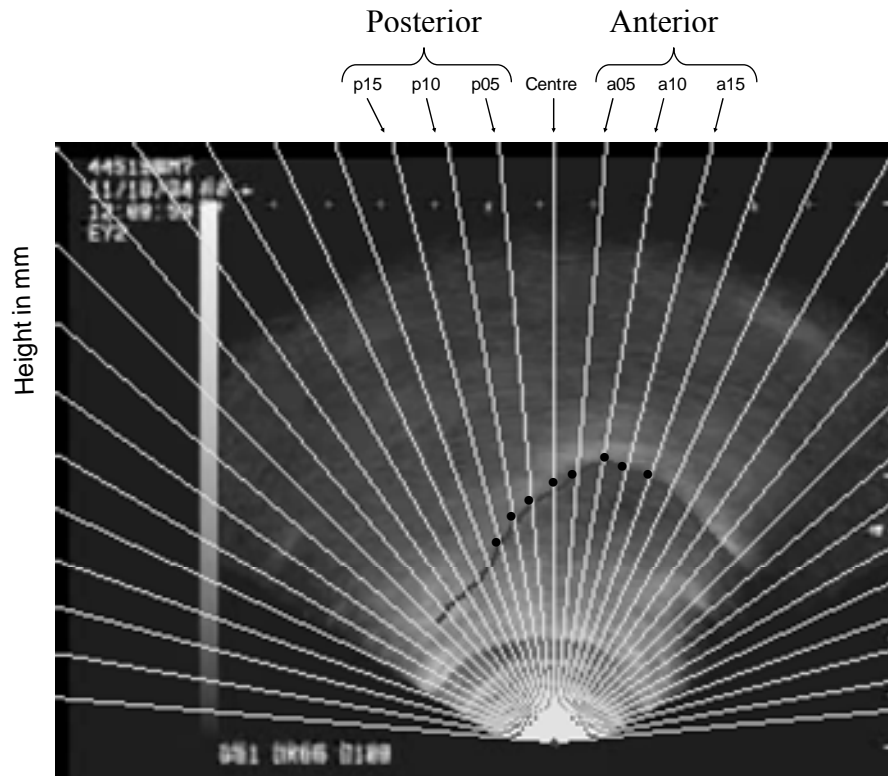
Ultrasound frame from the Ultra-CATS program showing different angles on a 5° grid that intersects with tongue tracing (black dots). ‘a’ denotes ‘anterior tongue’, ‘p’ denotes ‘posterior tongue’.
